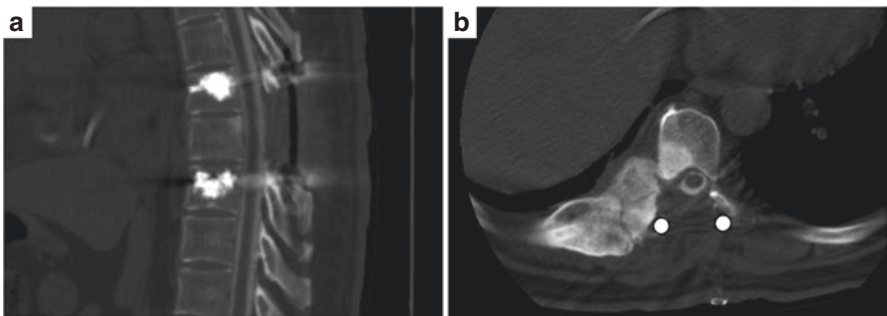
Postoperative CT myelogram demonstrating contrast filling through the thecal sac at the level of previous high-grade spinal cord compression. (a) Sagittal. (b) Axial
